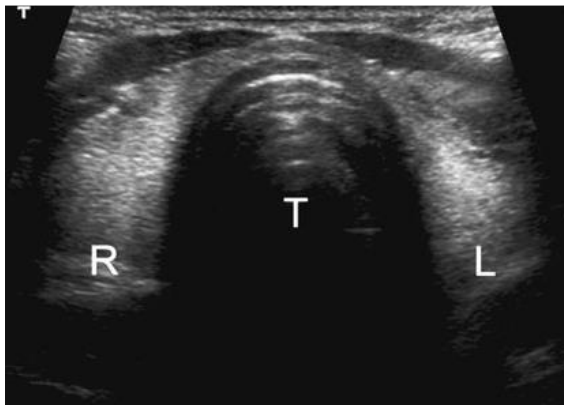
Ultrasound scanning. Transverse scan of a normal thyroid. R, right lobe; L, left lobe; T, trachea.
